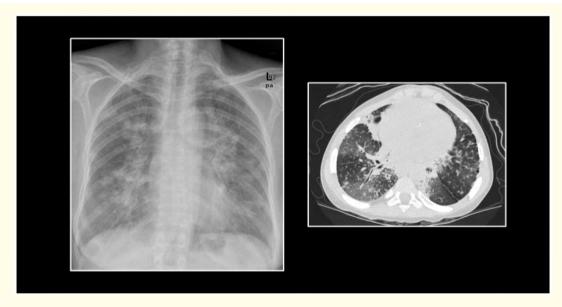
Histiocytosis X; a 33-year-old man with a long history of smoking, showing interstitial shadowing on a CXR and HRCT.
